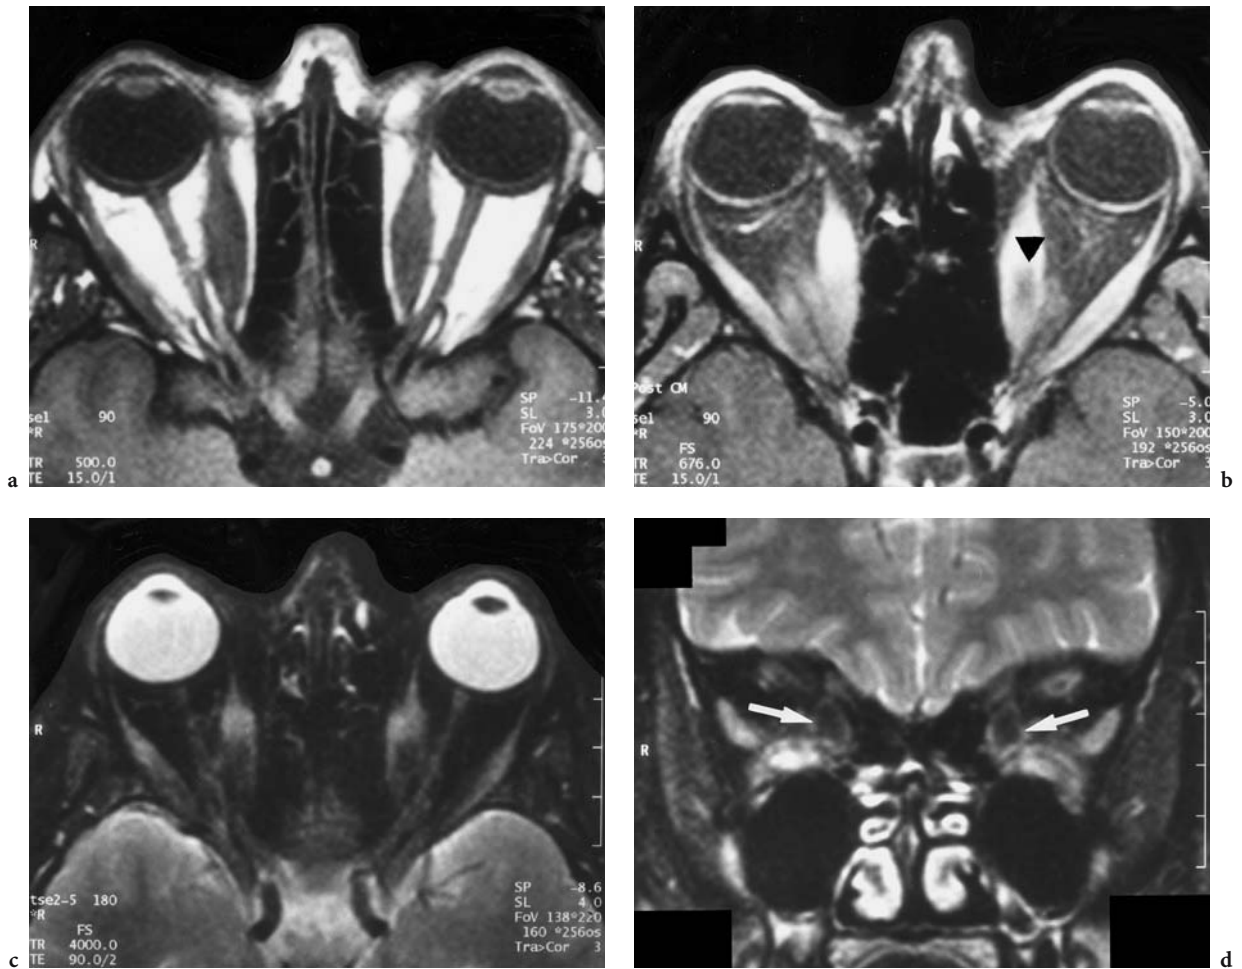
A 26-year-old woman with bilateral axial proptosis persisting for several years in the course of Graves' disease. Diagnosis: fatty degeneration in chronic Graves' disease. MRI: a Axial T1-weighted view, demonstrating a bilateral protrusion caused by the pouch-like, bilateral, symmetrical enlargement of the medial rectus muscles, sparing the tendons. b Corresponding T1-weighted, contrast-enhanced (FS) image showing a hypointense area in the left rectus muscle (*black arrowhead*), suspicions of fatty degeneration. c Corresponding T2-weighted (FS) acquisition confirming the presence of fatty degeneration by signal loss of the medial parts of both medial rectus muscles (*white arrows*). d Coronal T2-weighted view, signal loss of the areas of fatty degeneration is observed in the medial left as well as in both superior rectus muscles. (The hyperintensity of both inferior rectus muscles is due to susceptibility artifacts at the orbital floor)
